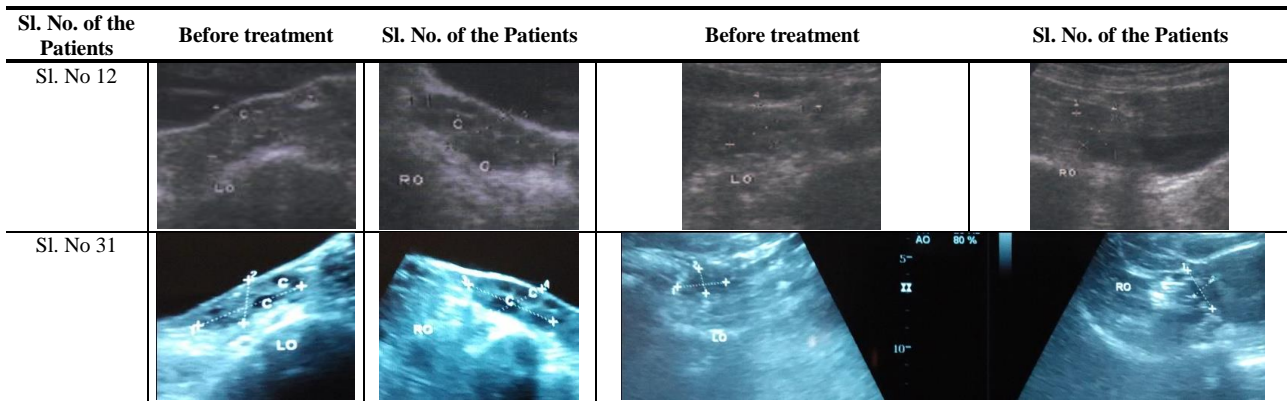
Images of Ultra sonography of the patients showing removal of cysts from ovary (left and right ovaries).
